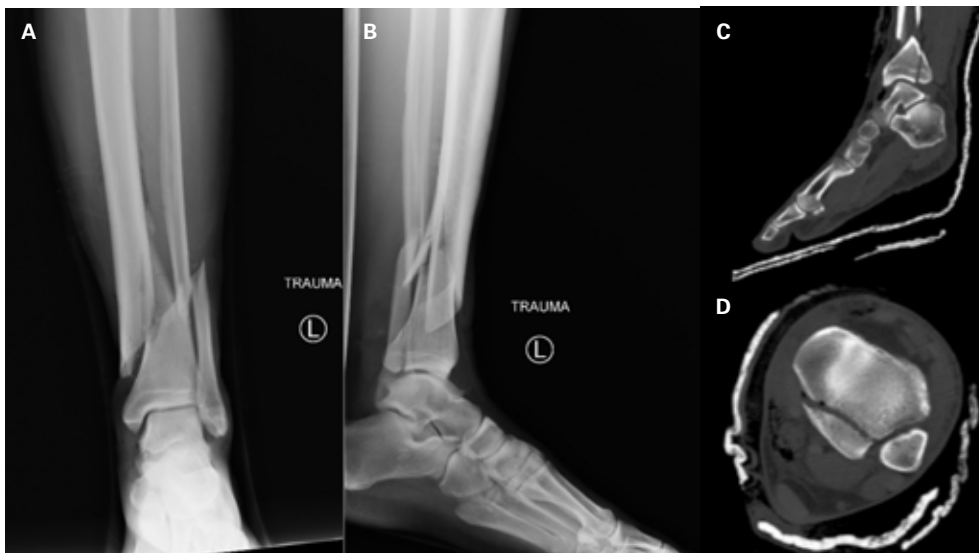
(A) Anteroposterior and (B) lateral radiographs of the left distal tibia showing spiral distal third tibia and fibula fractures and posterior malleolus fracture; (C) Sagittal and (D) axial CT slices further characterizing the non-displaced posterior malleolus fracture.
